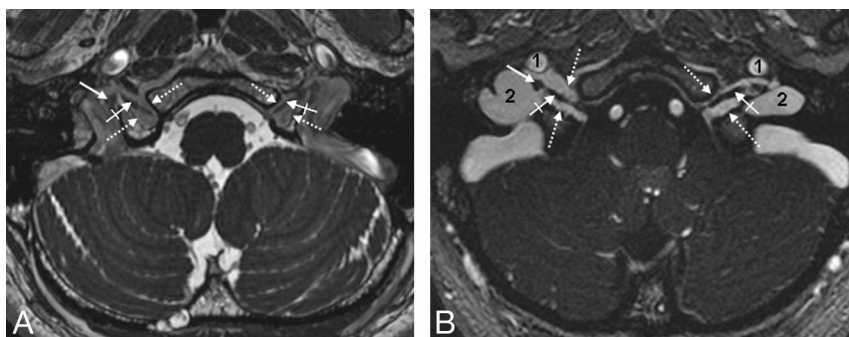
A* and *B*, CNXII within the hypoglossal canal. Axial FIESTA MR image (*A*) and CE-MRA image (*B*) clearly demonstrate the canalicular segment of CNXII. *Dotted arrows* indicate borders of the hypoglossal canal; *crossed arrows*, the canalicular segment of CNXII; *thin white arrows*, the CNX/XI complex within the JF; 1, the ICA; 2, the jugular bulb.
